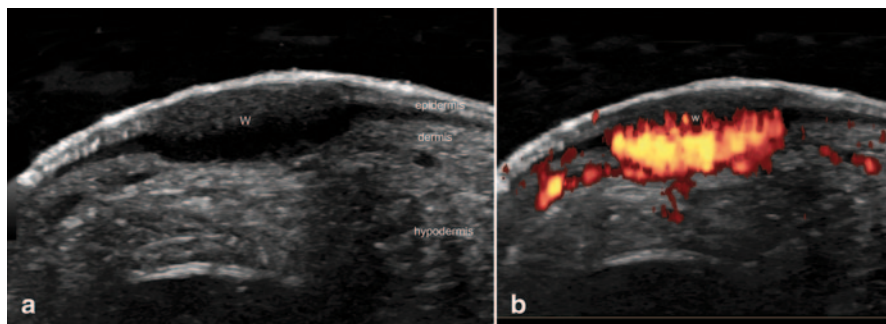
Plantar wart (*W*). a Ultrasound (*gray scale, transverse view*) shows hypoechoic fusiform structure in the epidermal and dermal region. b Power Doppler demonstrates increased blood flow to the lesion (*in color*) in the dermis and the underlying hypodermis
